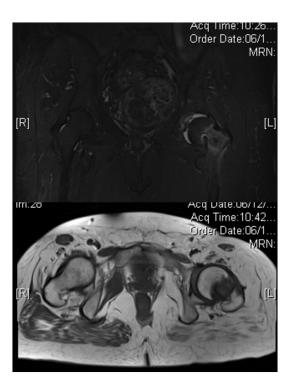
a) T2 coronal MRI and T1 axial MRI that excluded the vascular compromised of the femoral head.
